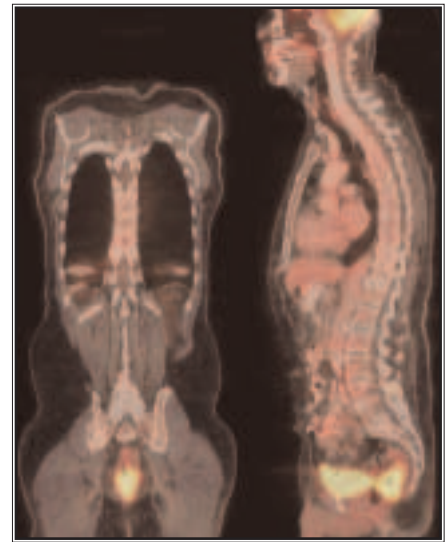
Fused PET/CT images. Note presacral mass with intense FDG uptake. Left: Coronal image through middle of tumor. Right: Sagittal image through midline.
